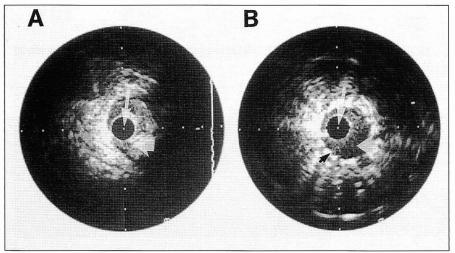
Intravascular ultrasound. (A) Prior to stent deployment, the ultrasound transducer (white arrow) is completely surrounded by atherosclerotic plaque (large white arrow). (B) After deployment of an intracoronary stent, a large lumen is created (large white arrow). Note struts of the stent (small black arrowhead) completely apposed to the vessel wall.
